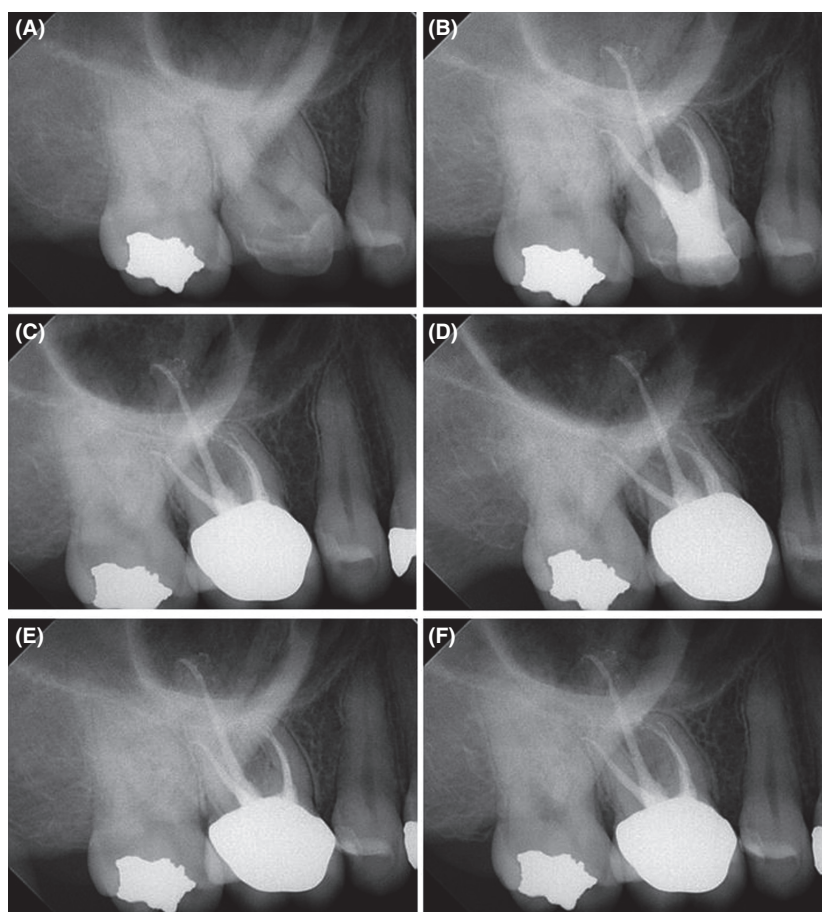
Radiographs (A) pre-GentleWave Procedure depicting periapical lesion on palatal root (B) post-GentleWave Procedure obturated root canal system with five distinct root canals (C) 3-month Post-GentleWave Procedure recall with healing periapical lesion (D) 6-month, (E) 12-month, and (F) 18-month Post-GentleWave Procedure recall with no evidence of periapical lesion.
